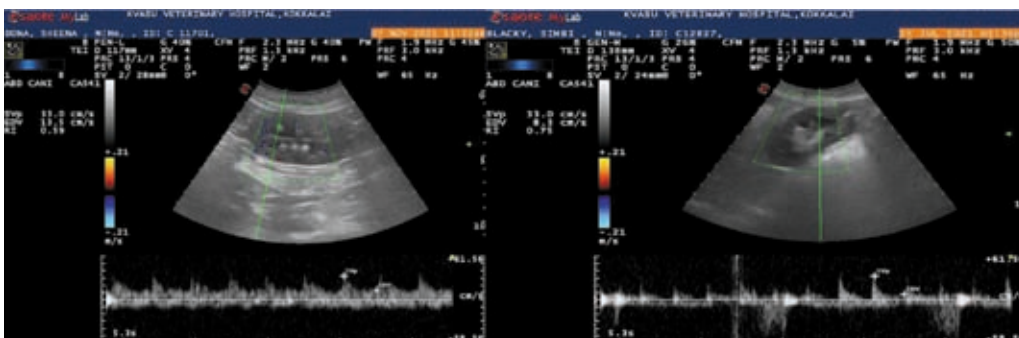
Doppler ultrasonographic measurement of RRI in interlobar artery of healthy kidney was 0.59 (left) and 0.75 in AKI (right).
